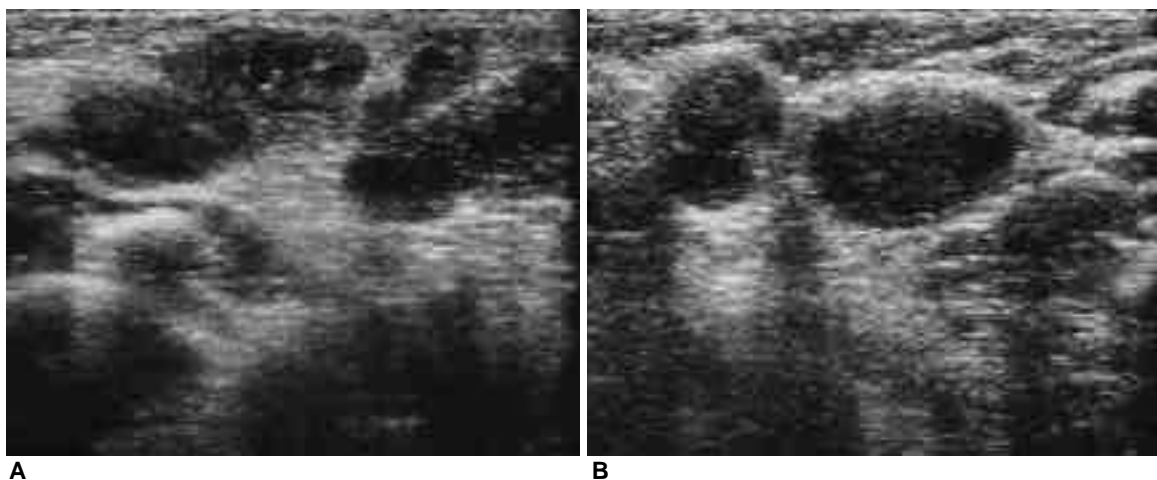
A 5-month-old female infant with multiple BCG lymphadenitis at the left supraclavicular (A) and axillary (B) areas. A. Ultrasonography shows multiple heterogeneous low echoic enlarged lymph nodes suggesting suppurative lymphadenitis with partly defined margins and posterior wall enhancement in the left supraclavicular area. B. Two oval-shaped heterogeneous low echoic lymph nodes are noted in the left axillary area with well-defined margins and posterior wall enhancements.
